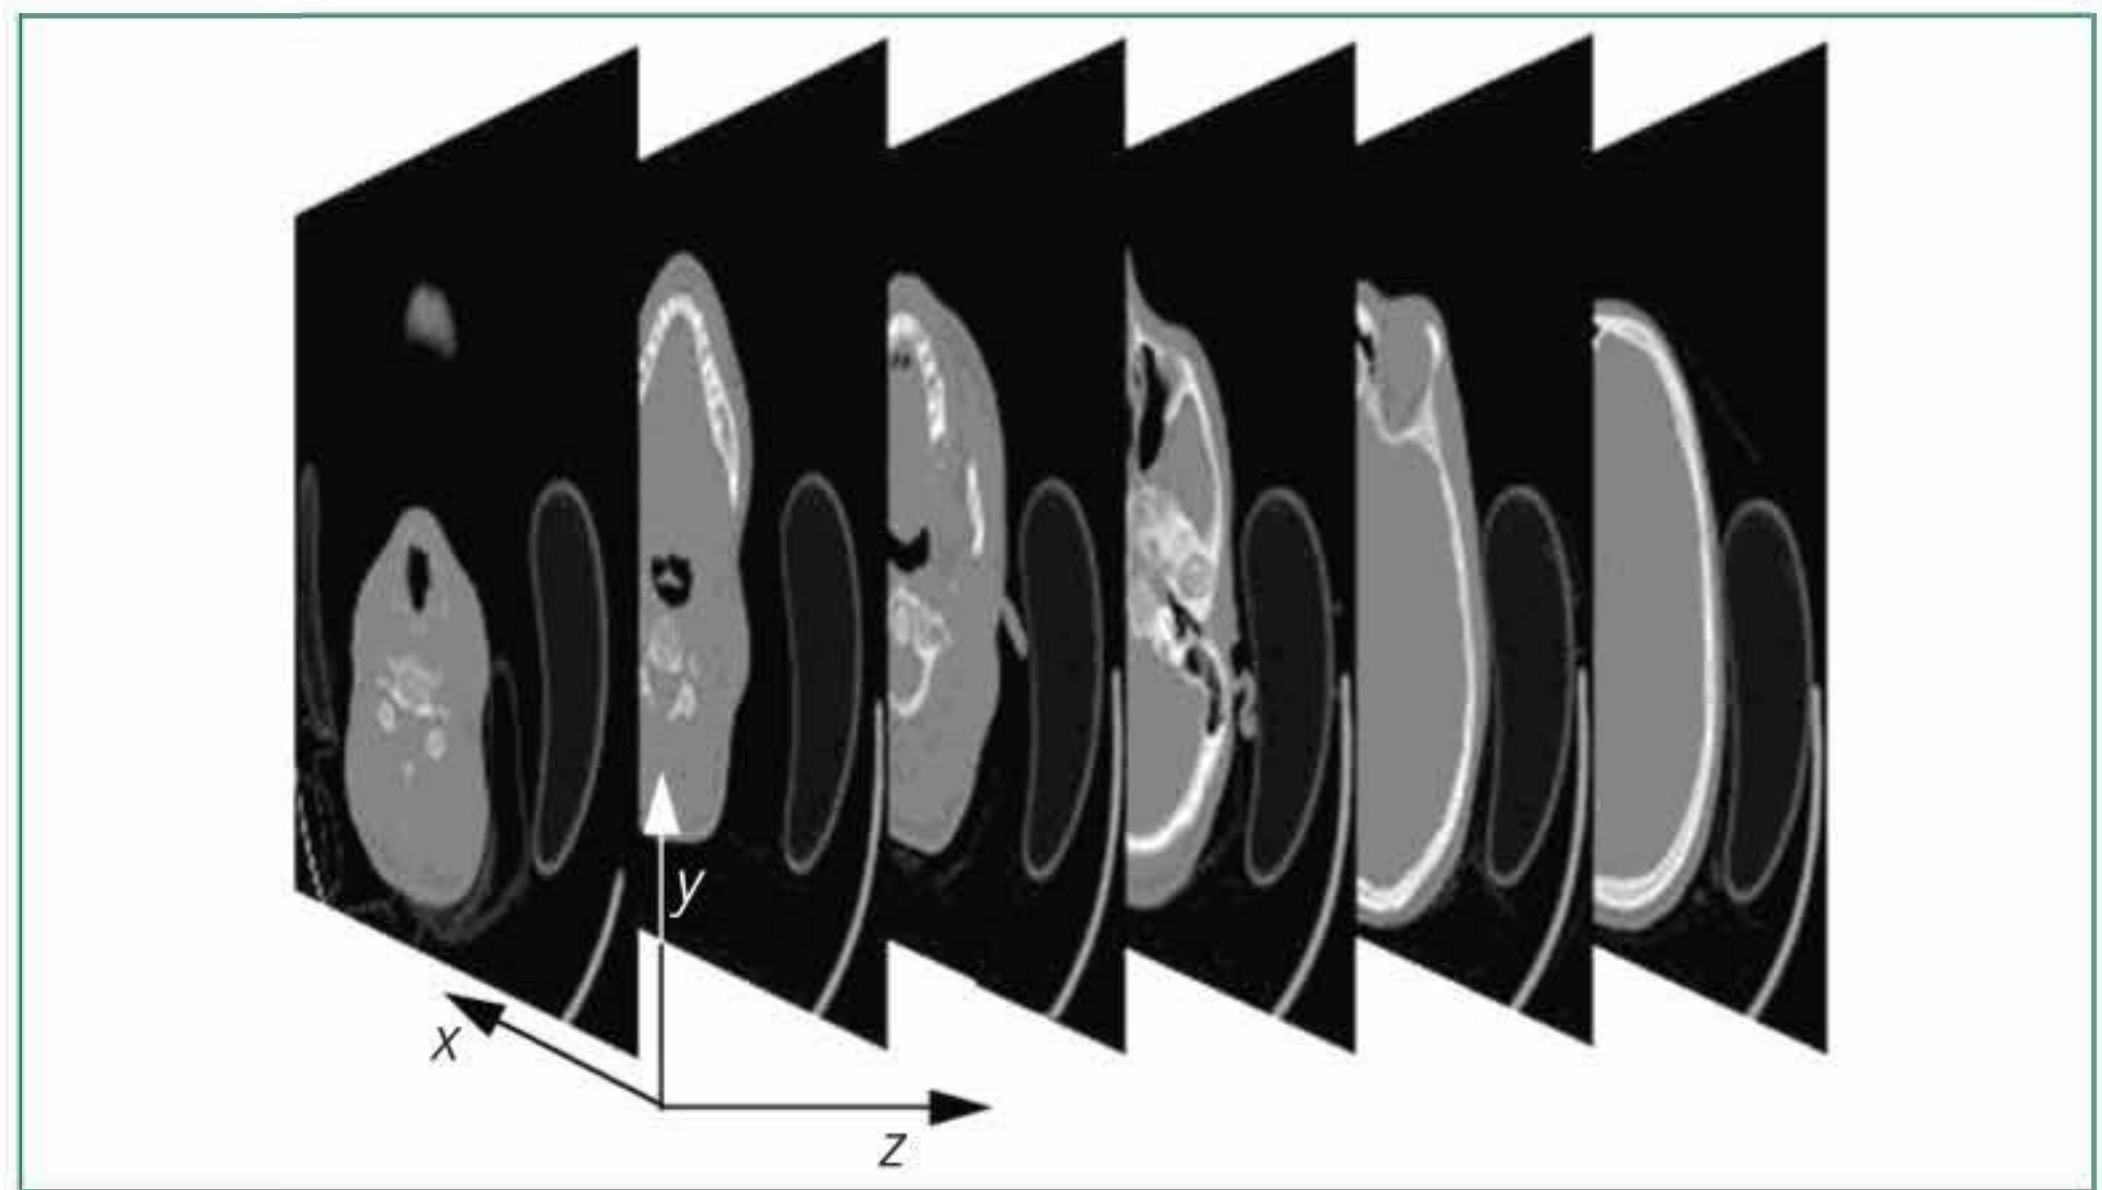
Computed tomography.
